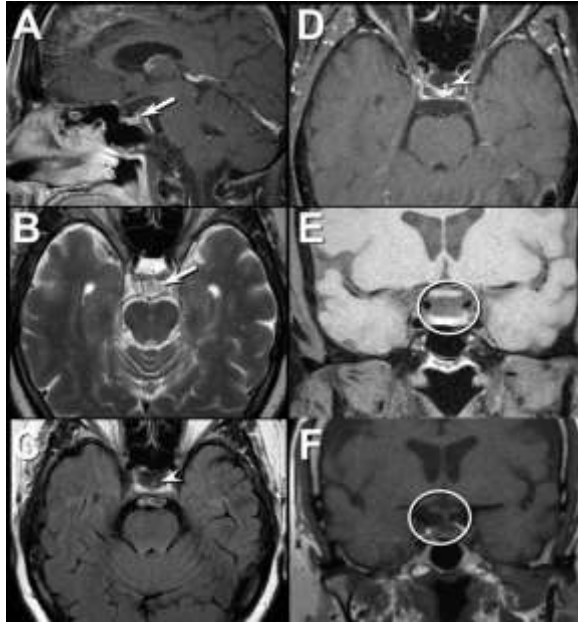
Brain MRI in the sagittal (A), axial (B-D) and coronal (E and F) planes shows a normal pituitary gland (arrows), sellar region (circle), and infundibulum (arrowhead). Click [here](#) to view Figure 3 in an enlarged separate window.
